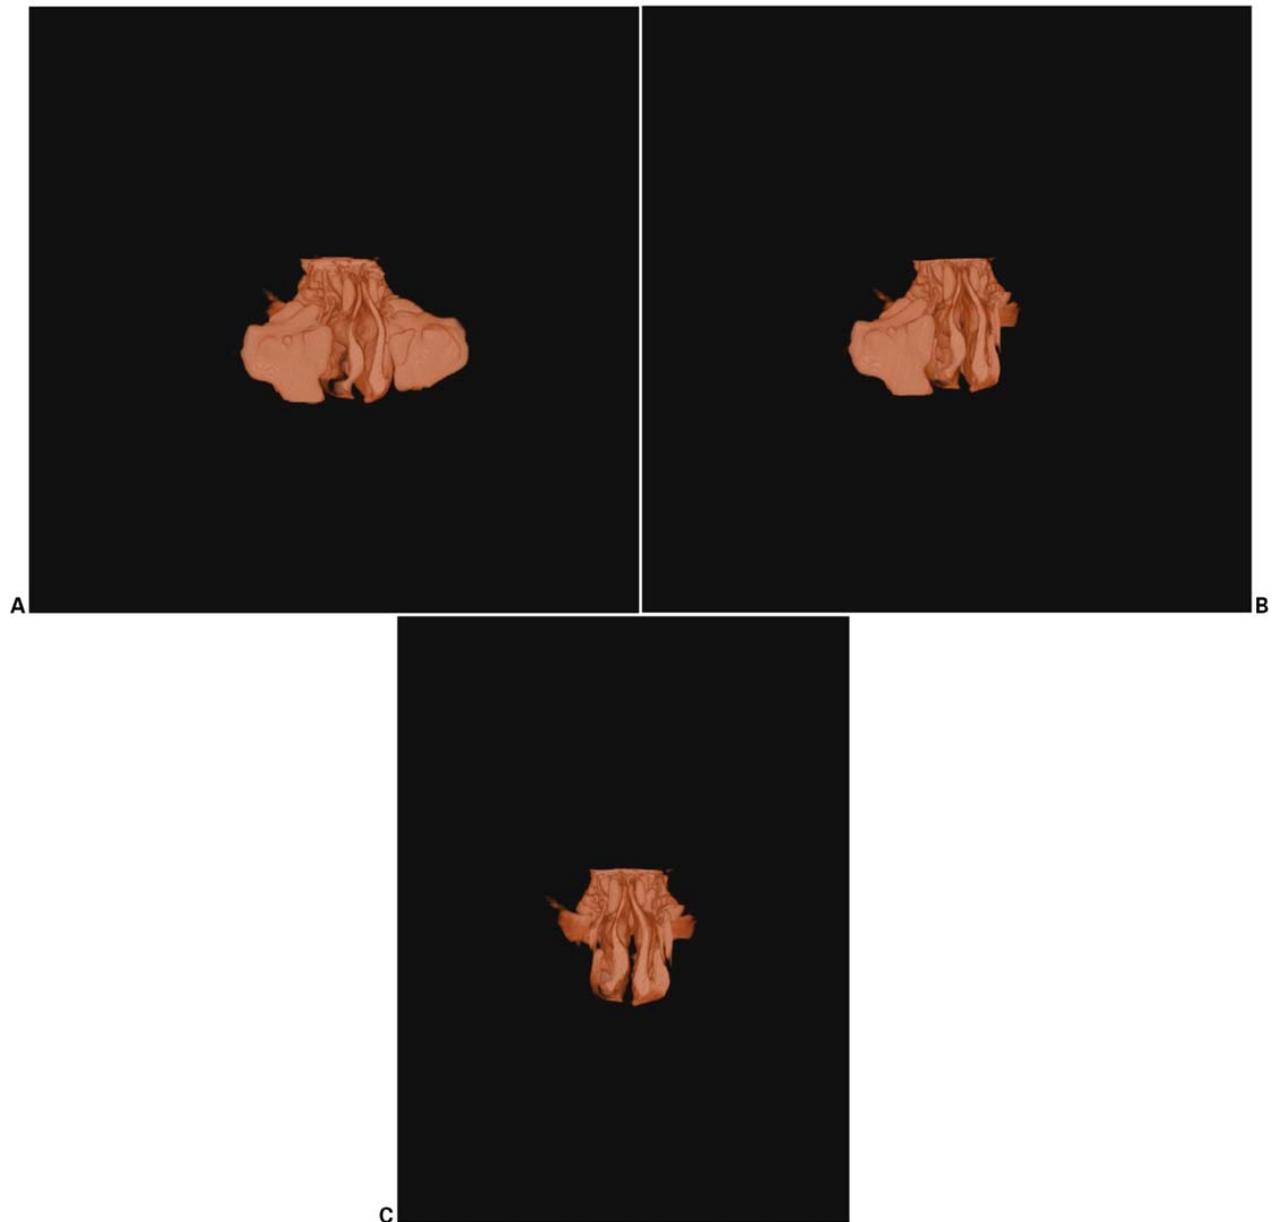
(A) For 3D reconstruction of the nasal cavity, appropriate software was implemented (Anatomage; inVivo Dental, San Jose, CA, USA). Pseudo-color objects were used to work on inverse volume reconstructions, which allowed visualization of spaces and trimming away the maxillary sinuses. (B) Object visualization was undertaken at each step when trimming away data from the CBCT data so that, eventually, the only information left was for volumetric reconstruction of the nasal cavity. (C) Volumetric reconstruction of the nasal cavity was undertaken between the anterior and posterior nasal spines, extending superiorly from the palatine process of the maxilla and the palatine bone to the cribriform plate of the ethmoid bone.
